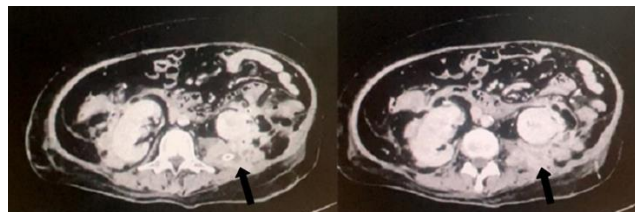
Abdominal contrast-enhanced CT Scan showed multiple retroperitoneal abscesses with the size of 8x5x4 cm in the right posterior hemiabdomen and 8x5x5 cm in the left hemiabdomen involving right and left musculus psoas and musculus quadratus lumborum extending to perirenal
